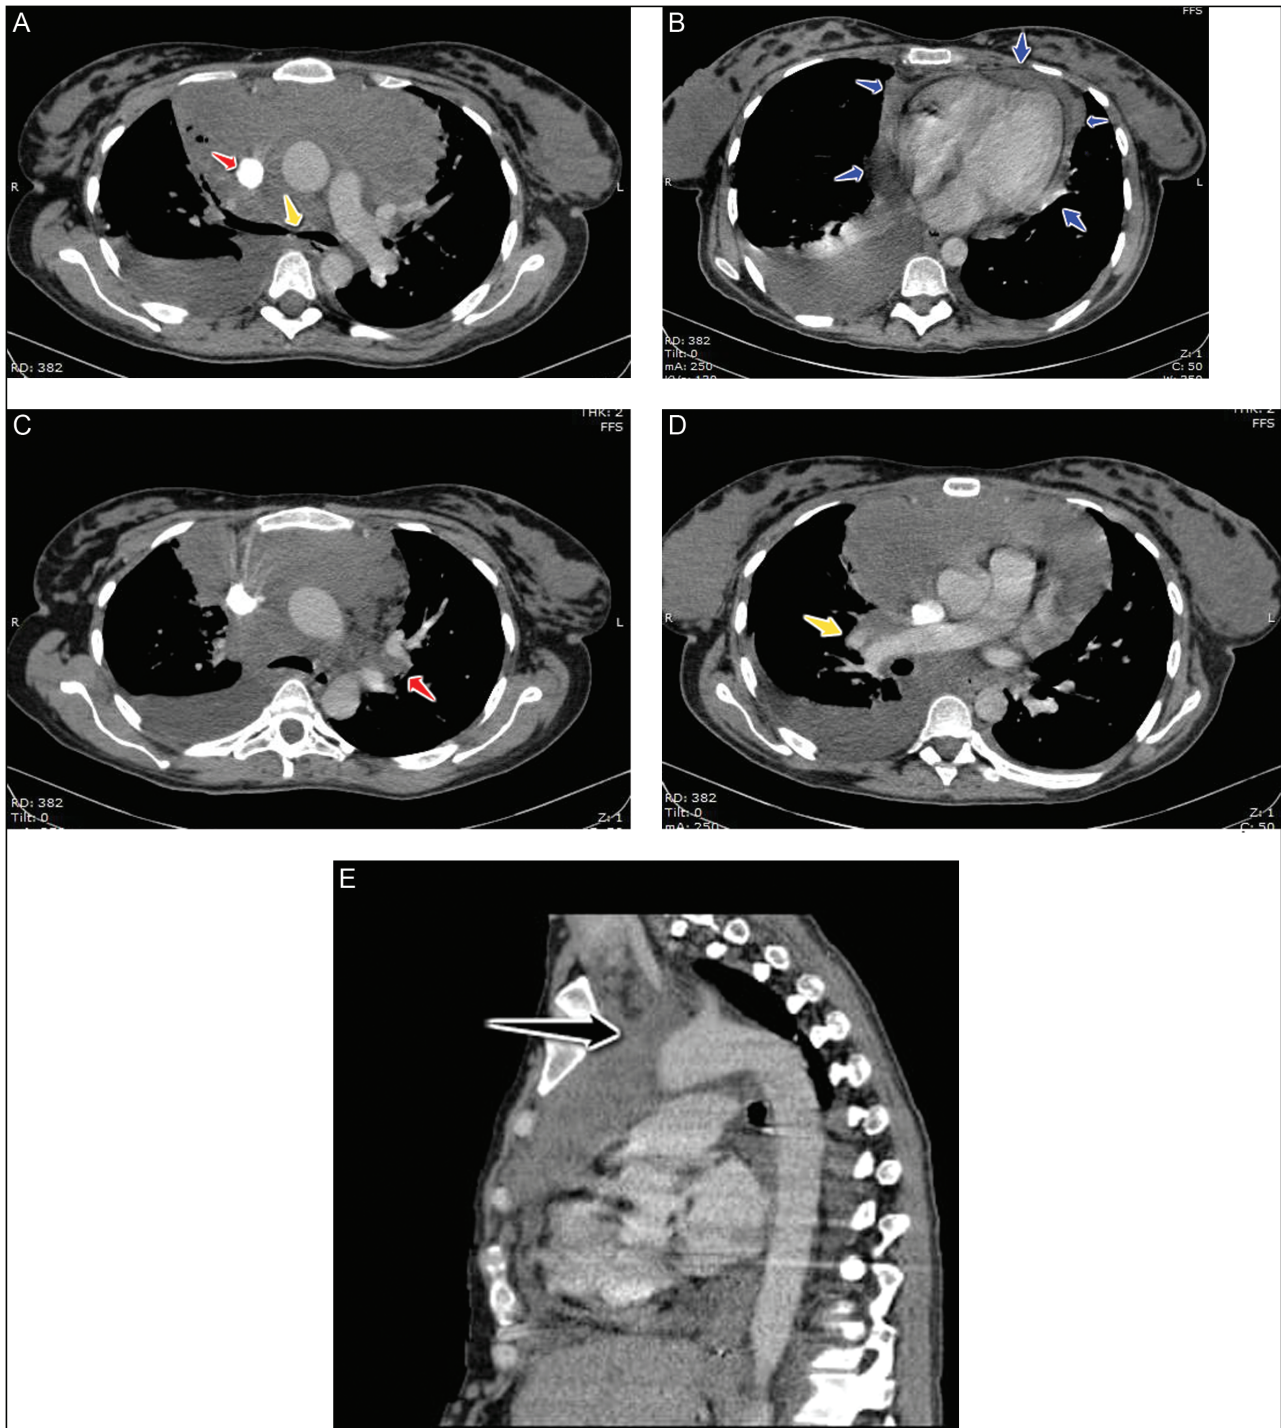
(A) Axial view of computed tomography showing extensively enlarged lymph nodes exerting pressure on the carina (yellow arrow) and the superior vena cava (red arrow). (B) Axial view of computed tomography showing a large pericardial effusion (blue arrows). (C) Axial view of computed tomography showing enlarged left (red arrow) hilar lymph nodes, which appear matted together. (D) Axial view of computed tomography showing enlarged right (yellow arrow) hilar lymph nodes, which appear matted together. (E) Sagittal view of computed tomography showing extensively enlarged matted superior mediastinal lymph nodes (black arrow)
